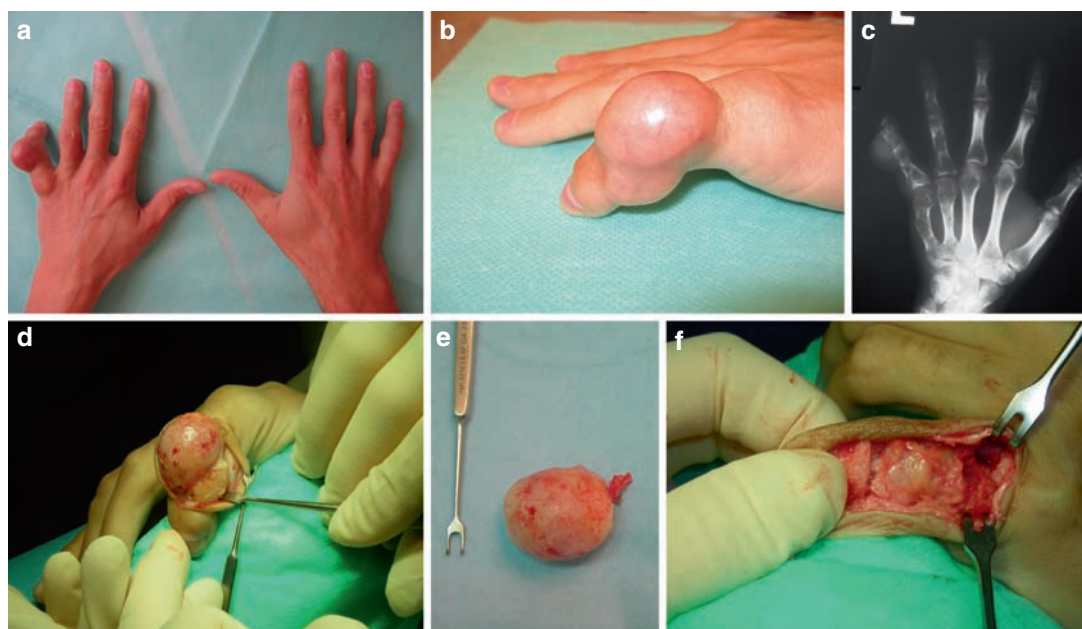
Chondrosarcoma of the little finger. (a, b) Clinical presentation. (c) X-ray. (d) Intraoperative view. (e) Excised tumor. (f) Site after tumor excision.
